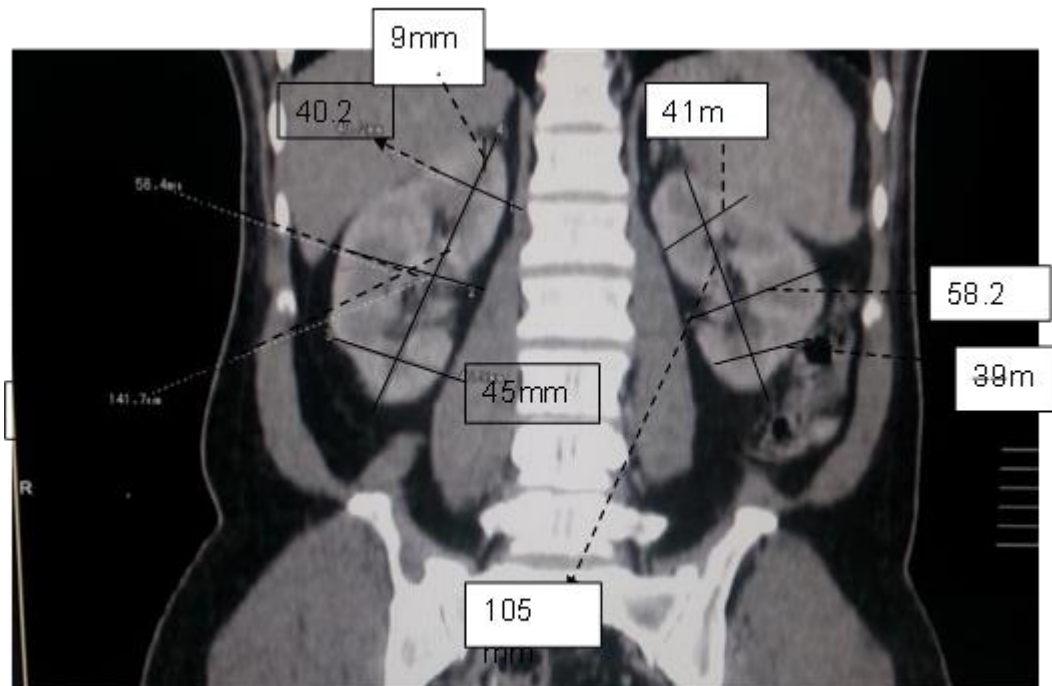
coronal CT image for female (27years) show site measurements of RT Kidney length, width and cortical thickness diameters.
